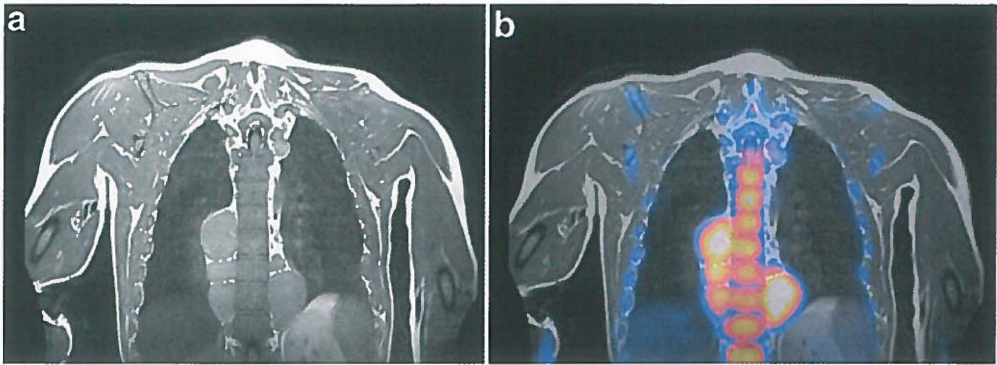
A: MRI thorax with a mass paravertebral, B: Fused ^{18}F -FLT-PET-MRI shows an elevated ^{18}F -FLT uptake paravertebral due to extramedullary hematopoiesis.
